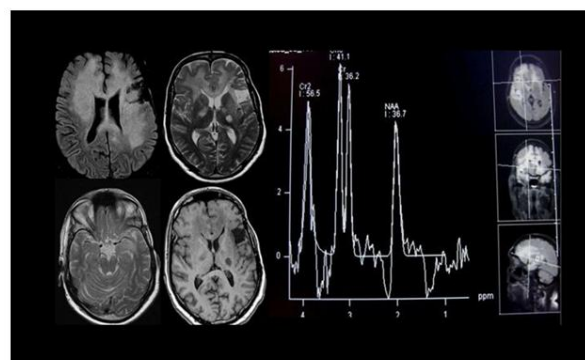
The MRI slices show diffuse signal intensity in bilateral frontal lobes involving the cortex and white matter. There is the tumor resection site. This patient underwent post resection radiation therapy. The question is whether the signal intensities represent recurrence or not? Conventional MRI is inconclusive so MRS is obtained showing Cho/Cr ratio of 4, high lactate and decreased NAA. The pattern is suggestive for tumor progression. *Courtesy of H.Hadizadeh*
